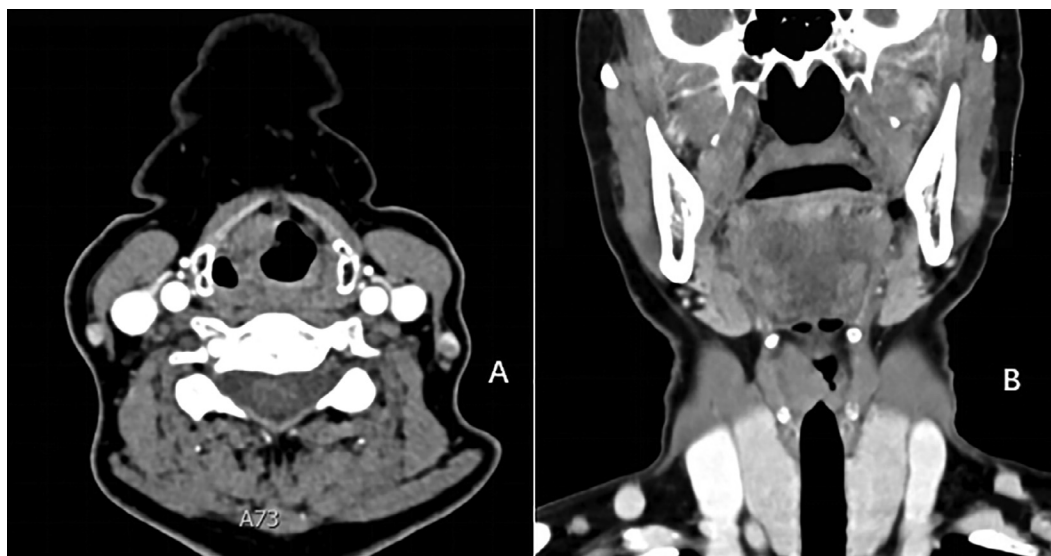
Computed tomography scan showing a heterogeneous soft-tissue mass situated in the right vocal cord.
